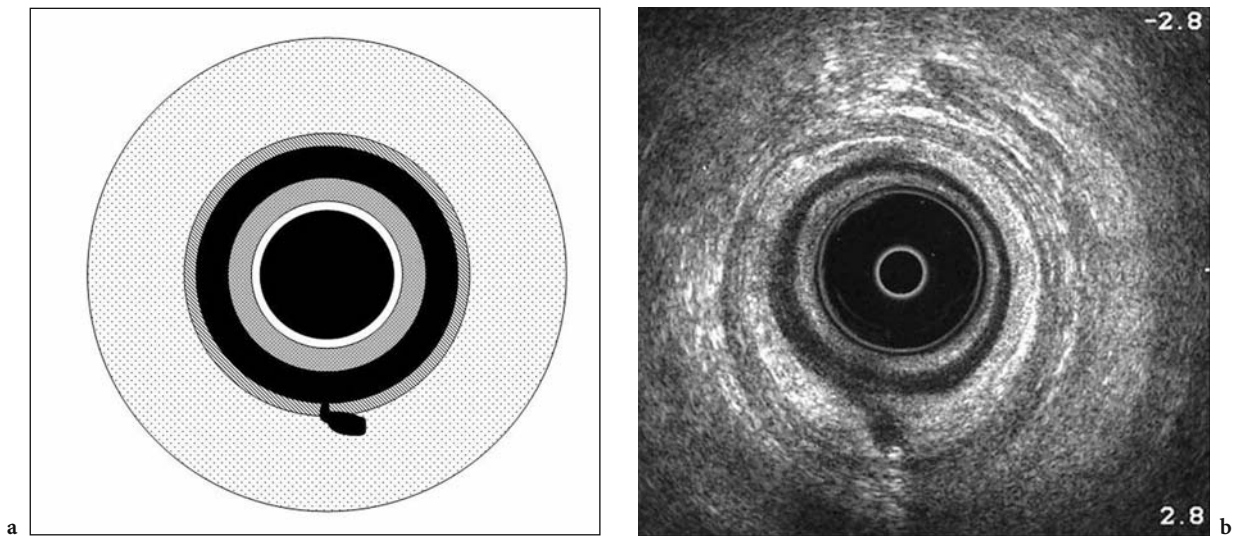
First endosonographic criteria for the site of an internal opening according to Cho [17]: an appearance of a root-like budding formed by the intersphincteric tract, which contacts the internal sphincter (a, b)
